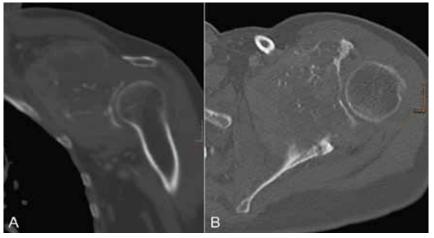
The coronar (A) and axial (B) computed tomographic (CT) image of the left shoulder shows an expansive honeycomb-like tumour of the glenoid with cortical destruction and now predominantly soft tissue mass with small areas of ossification.
